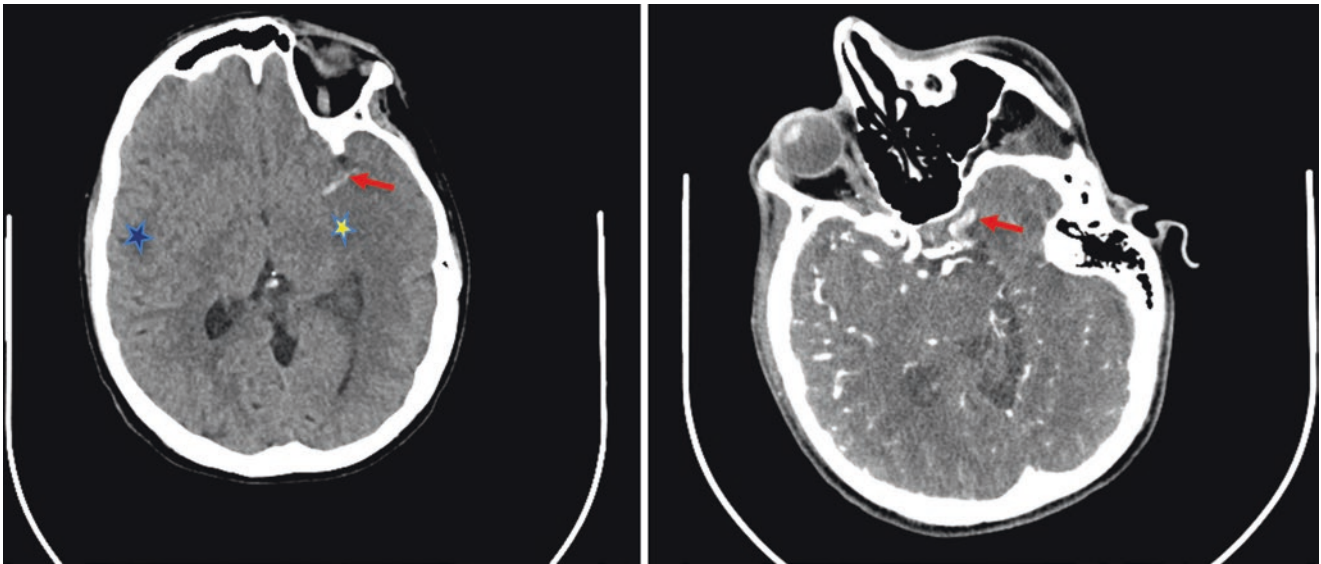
47-year-old woman with history of left oral cancer, treated with radiation and chemotherapy 7 years before. She came to the ED with acute onset aphasia, right hemiparesis, and fall. National Institutes of Health (NIH) Stroke Scale score: 20. CT of head (*left panel, arrow*): classic hyperdense middle cerebral artery (MCA) sign from acute
